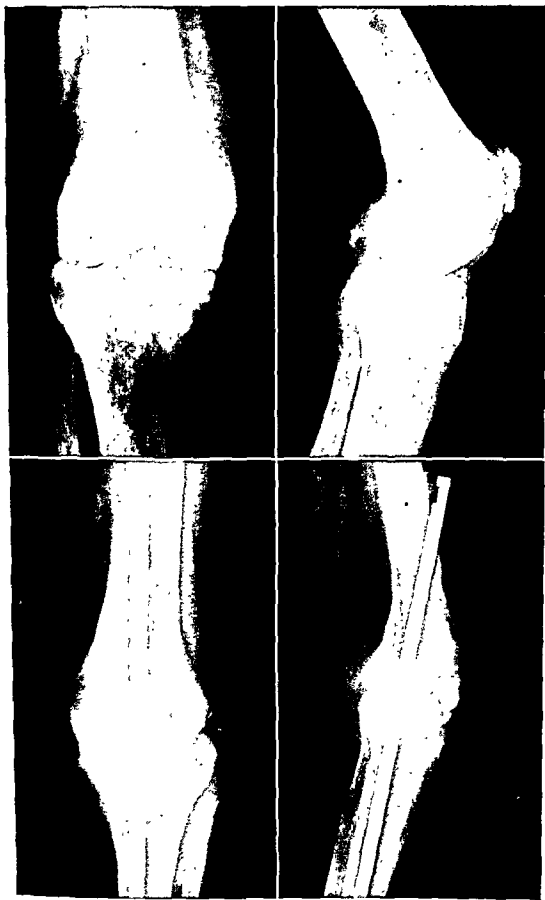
Fusion of arthritic knee with the aid of an intramedullary rod. (Top, left & right) Preoperative anteroposterior roentgenogram of the knee of a woman with painful rheumatoid arthritis (Bottom, left & right) The same 6 months after surgical fusion and insertion of intramedullary rod.
